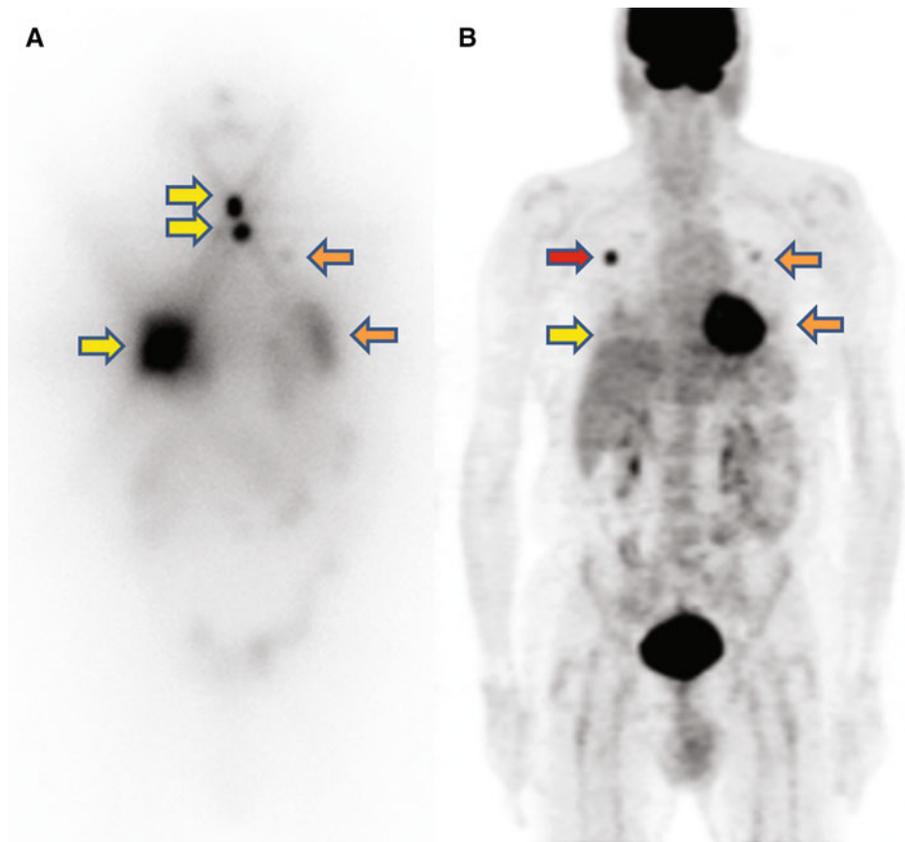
^{131}I WBS (a) and ^{18}F FDG PET (b) in a 70-year-old male patient with increased Tg levels after thyroidectomy for a DTC. ^{131}I WBS detected increased tracer uptake corresponding to local recurrence and pulmonary lesions. ^{18}F FDG PET detected an additional lung lesion missed by ^{131}I WBS (red arrow), whereas other lesions showed similar (orange arrows) or lower or absent radiopharmaceutical uptake compared to ^{131}I WBS (yellow arrows) (color figure online)
